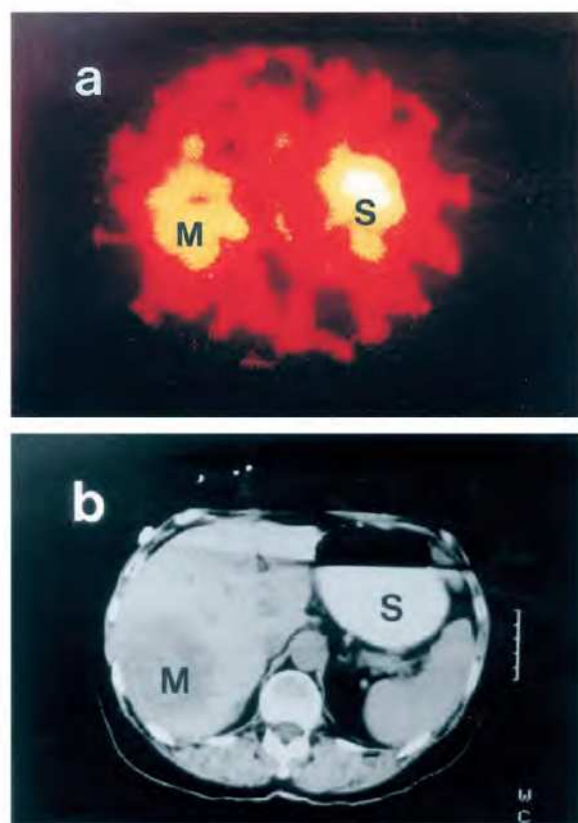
A5CP localization in liver metastasis. *a*, SPECT image in patient three 52 h after A5CP administration, showing the localization of the conjugate within a liver metastasis (M). Free ^{131}I is also seen in the stomach (S). *b*, corresponding CT scan through the liver showing the large posterolateral metastasis (M). S, stomach.
